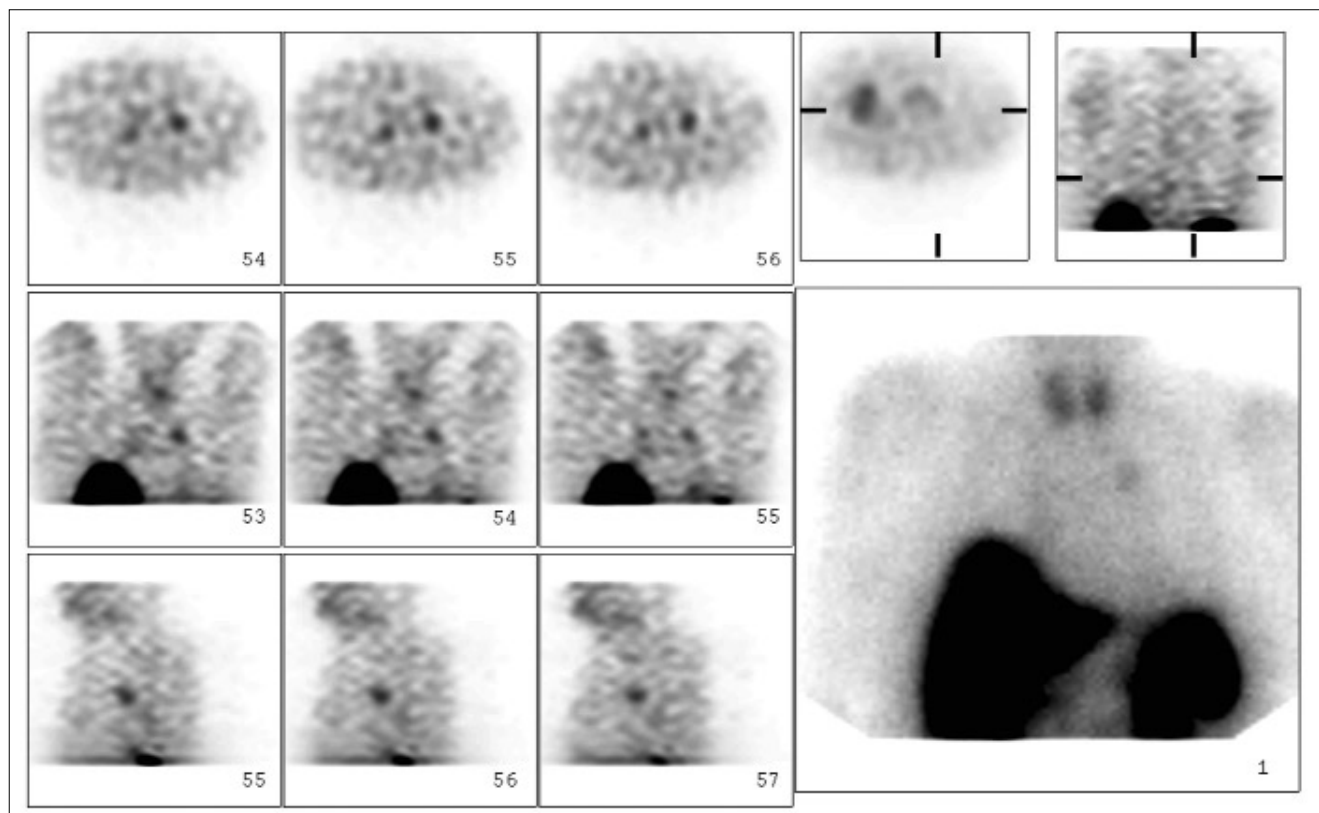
Tumour of the lung causing TIO localized by ¹¹¹In-octreotide scintigraphy.
